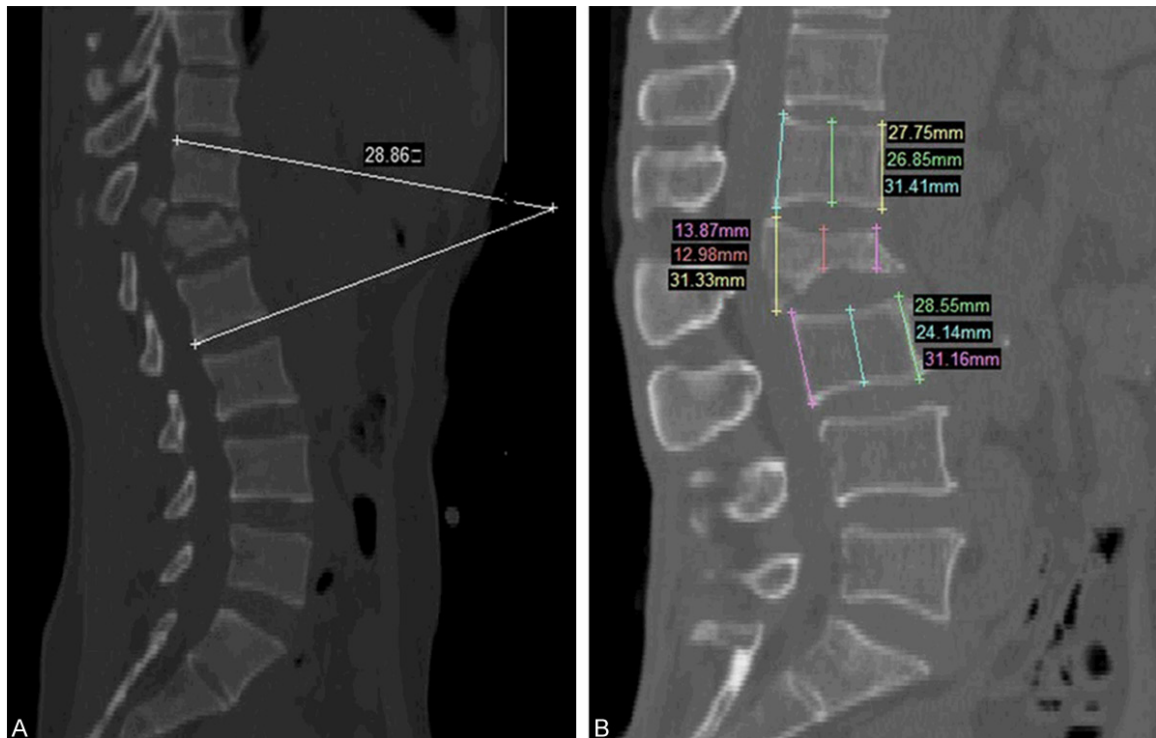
Mid-sagittal CT images. A. The kyphosis was 34.68° on the mid-sagittal CT image. B. Heights of Anterior, middle, and posterior wall of injury vertebrae and vertebrae above or below the injury vertebra on the mid-sagittal CT image.
